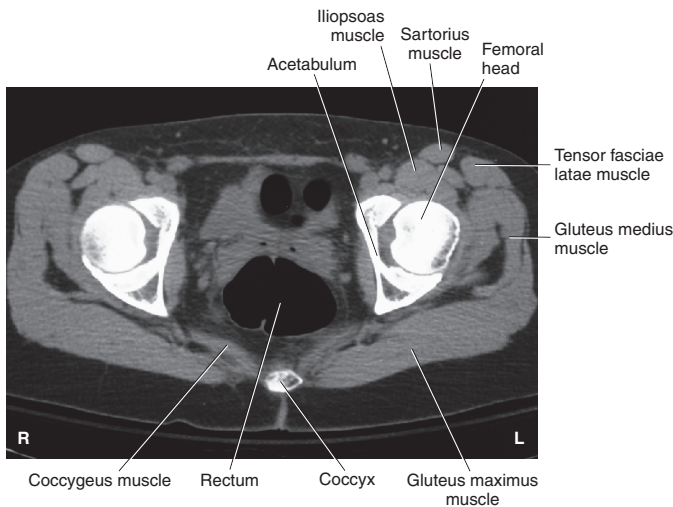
Axial CT of hips.
